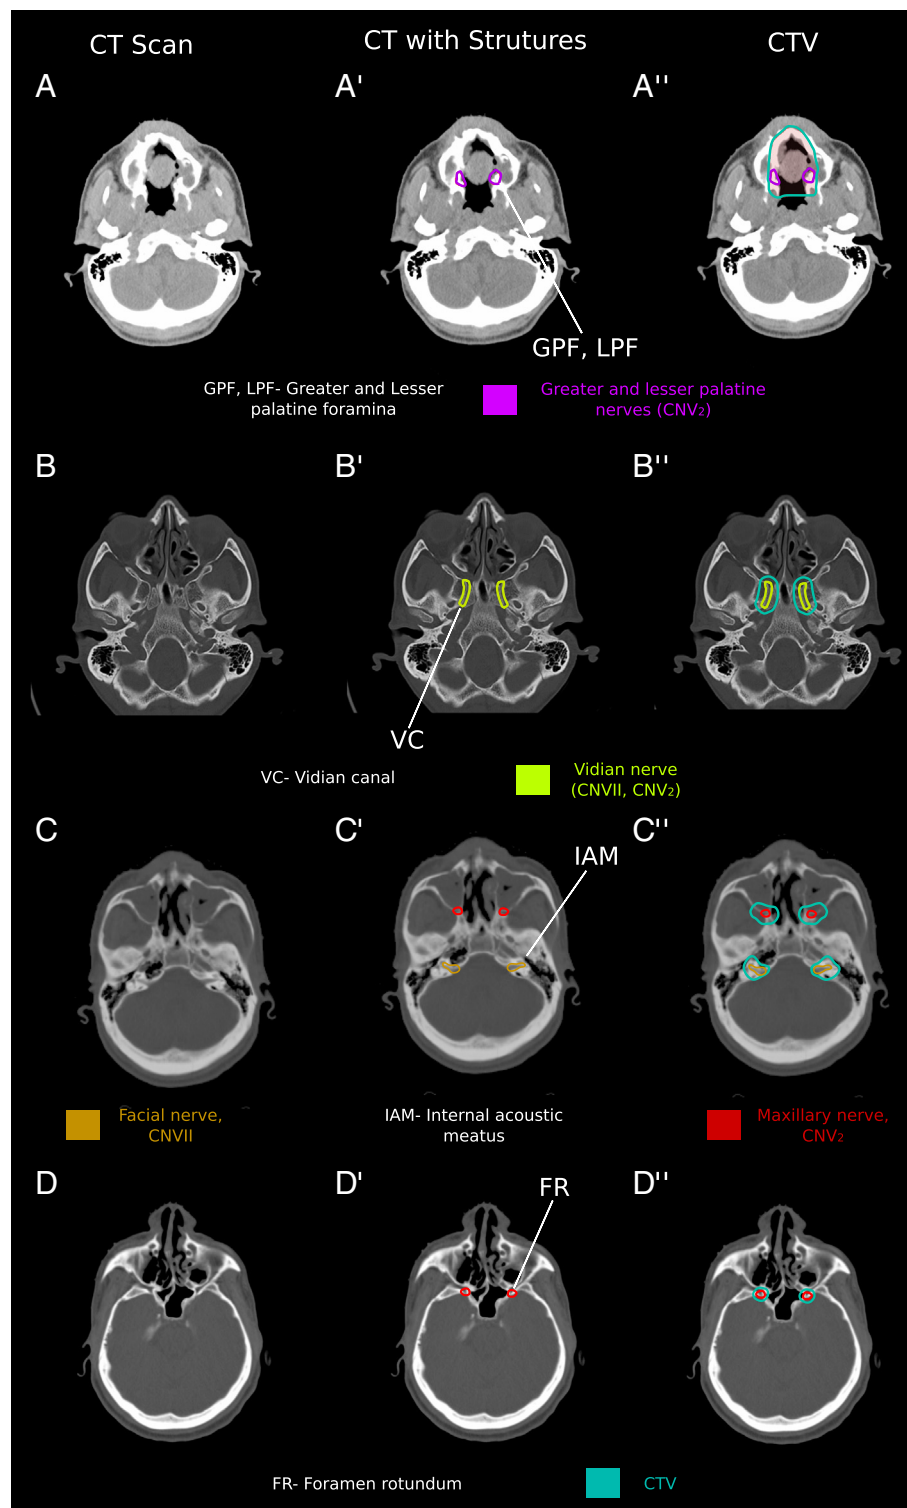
Axial computed tomographic (CT) slices of the hard palate and related cranial nerves. The left column (A-D) depicts axial CT images of the area of interest, the middle column (A'-D') depicts the nerves contoured on CT images, and the right (A''-D'') depicts these contours with a clinical target volume (CTV; shown in teal). The maxillary nerve (cranial nerve [CN] V₂) (shown in red) and its branches, the greater and lesser palatine nerves (shown in purple), provide innervation to the hard palate. The facial nerve (CN VII) (shown in gold), can also be involved in cancers of the hard palate, through the vidian nerve (shown in yellow-green). The maxillary nerve, the facial nerve, and their aforementioned respective branches are at risk for harboring cancer in the setting of perineural invasion. (IAM, internal acoustic meatus.)
